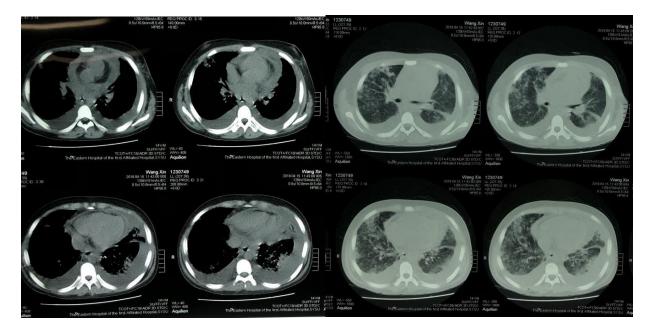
Chest CT when admitted to ICU.
